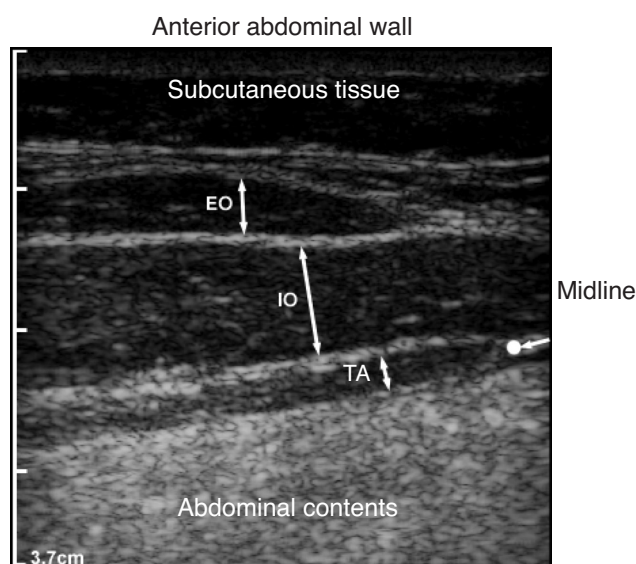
A transverse view of an ultrasound image of a subject's relaxed anterolateral abdominal wall. The single arrow and white-filled circle indicate the medial border of the transversus abdominis (TA) muscle where its fascia blends with that of the internal oblique (IO) muscle. The double arrows indicate the width of each of the abdominal muscles, TA, IO, and external oblique (EO), which are separated by fascial planes that appear as white lines on the ultrasound image. The scale on the left side of the ultrasound image indicates the depth.
